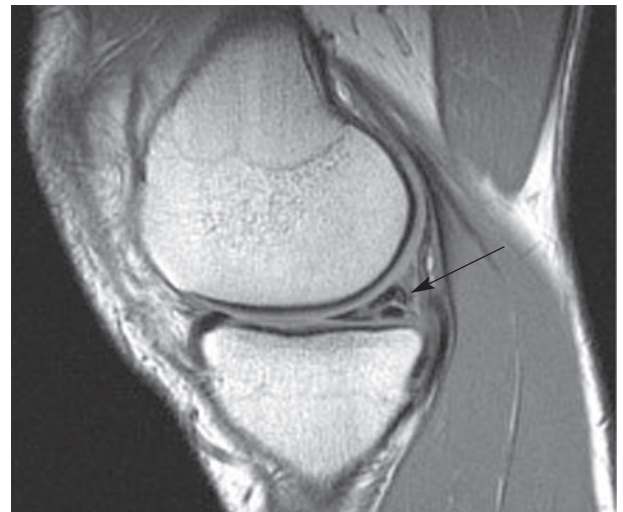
Magnetic resonance imaging MRI is ideal for displaying soft-tissue injuries, particularly tears of the menisci of the knee; this common injury is clearly shown in the picture.
